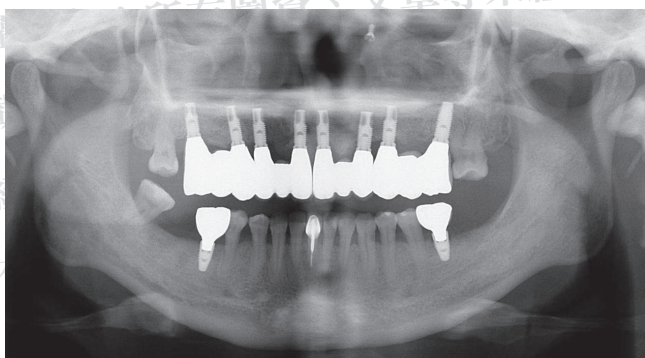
Panoramic radiograph after insertion of definitive FDPs.
